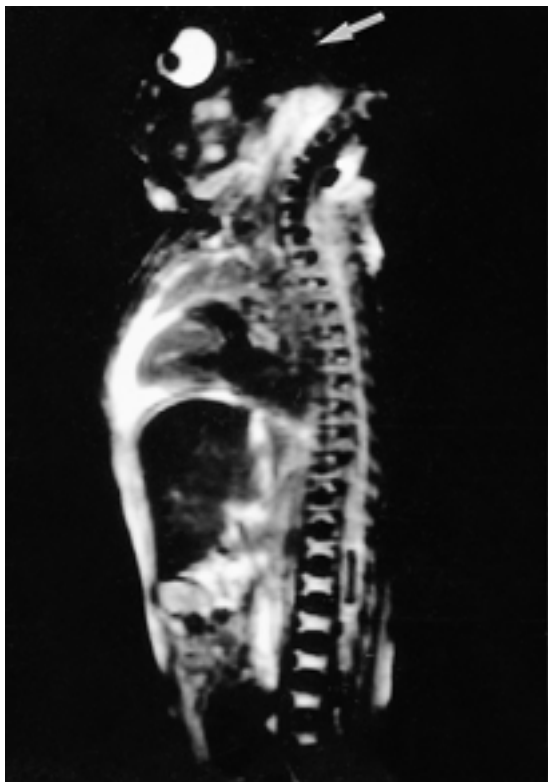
MR image of an anencephaly fetus.
